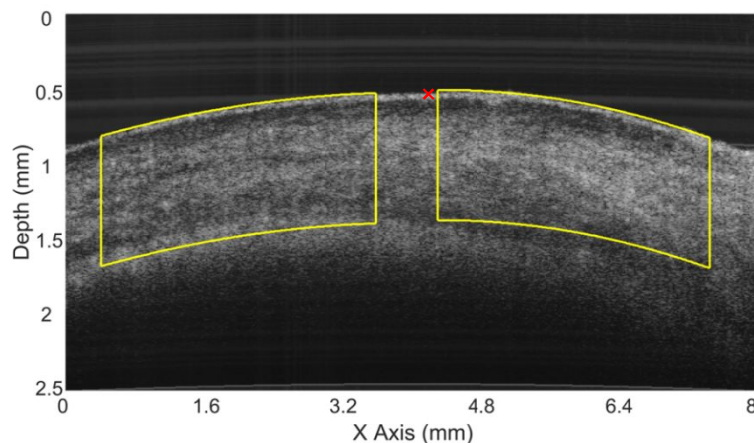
OCT structural image of a typical sample. The yellow boxes indicate the elastic wave calculation regions, and the red cross indicates the ultrasound induced excitation position.
